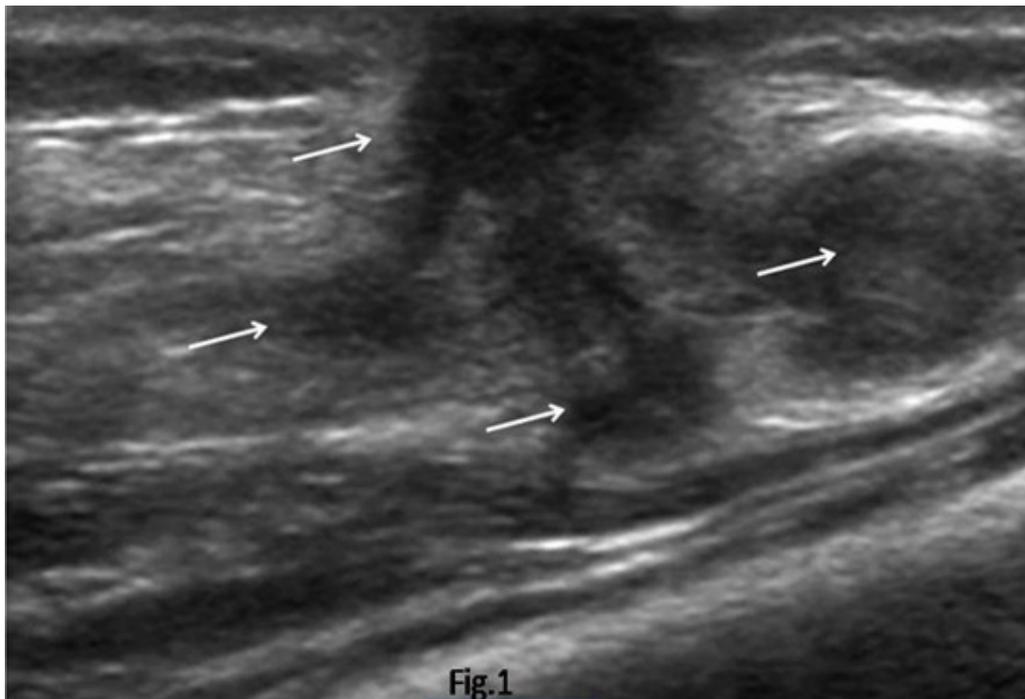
High resolution contrast ultrasound in longitudinal plane revealing area of heterogenous echotexture (arrowa) in right quadriceps femoris suggestive of pyomyositis
